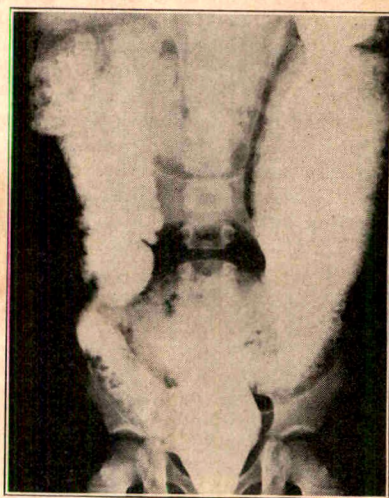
(case 7).—Enlargement of the entire colon and the rectum in a 6 year old patient, demonstrated by a postevacuation roentgenogram taken after the patient had had an enema of barium sulfate. Symptoms subsided after a sympathectomy. The patient is living and well at the age of 17.
